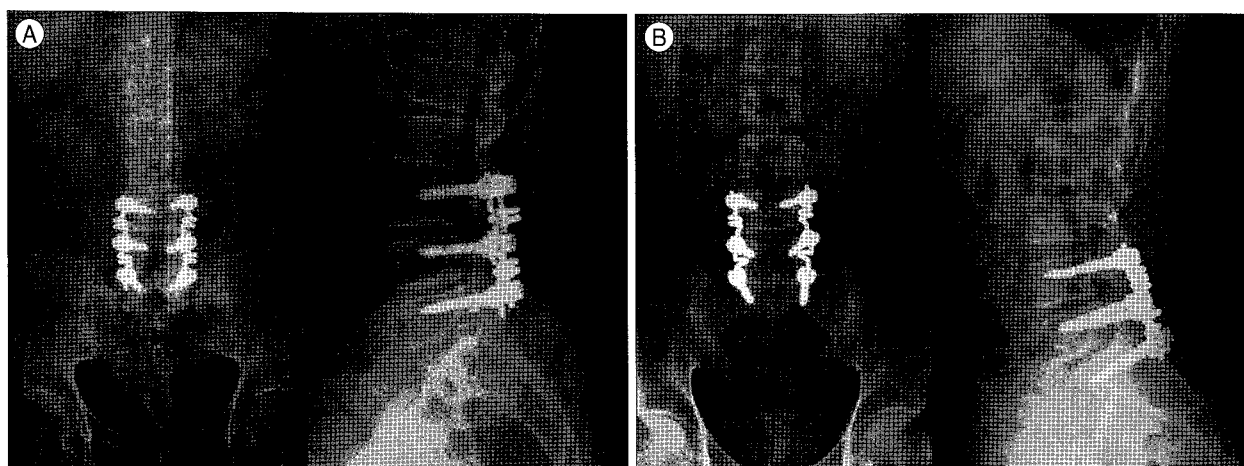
Plain X-ray films showing L3-4-5 constructs (A) and L4-5-S1 constructs (B). For L3-4-5 lesions, upper laminectomy was performed from L3 lower to L5 (A), and for L4-5-S lesions it was performed from L4 lower to S1 (B).
